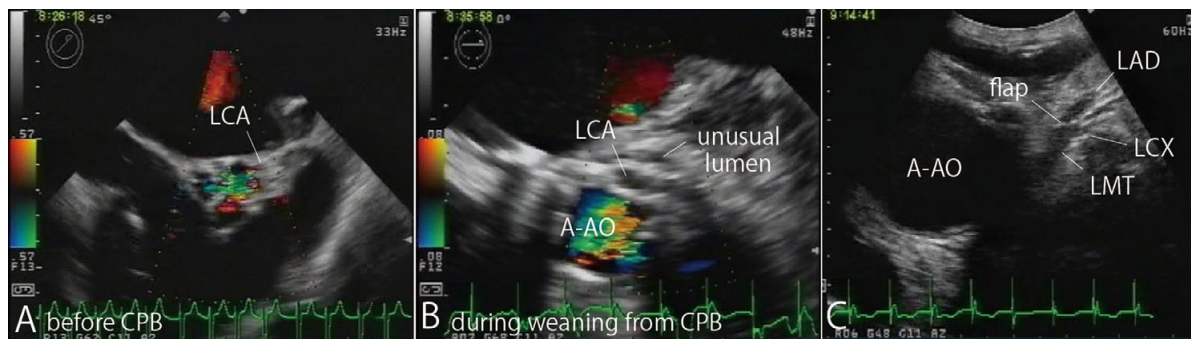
Transesophageal echocardiograms and epicardial ultrasonography of intraoperative dissection in the left main trunk (LMT). (A) Intact LMT before cardiopulmonary bypass (CPB). (B) An unusual lumen was observed, but LMT flow became undetectable. A-AO, ascending aorta. (C) A flap occluded the left anterior descending artery (LAD). LCX, left circumflex artery.
